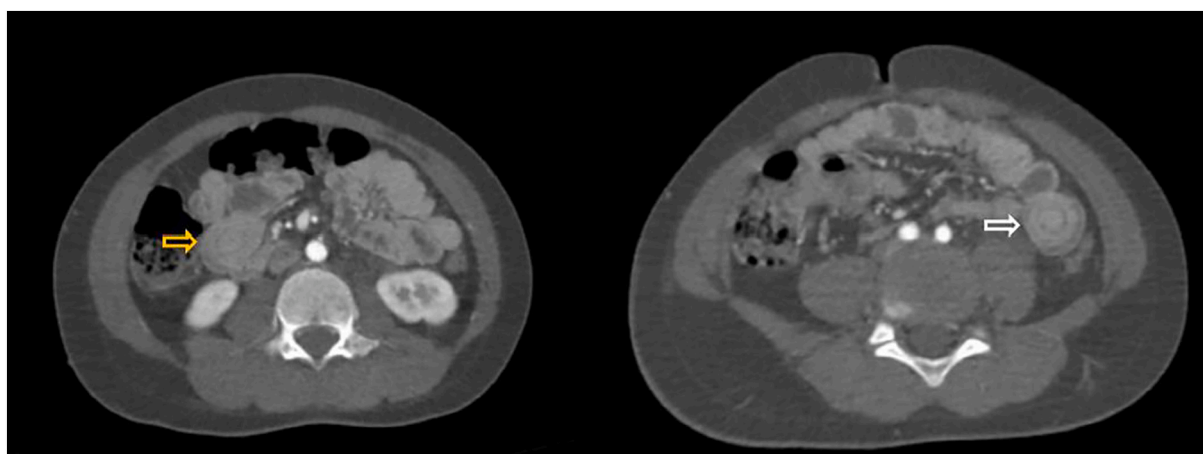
Abdominal CT scan
